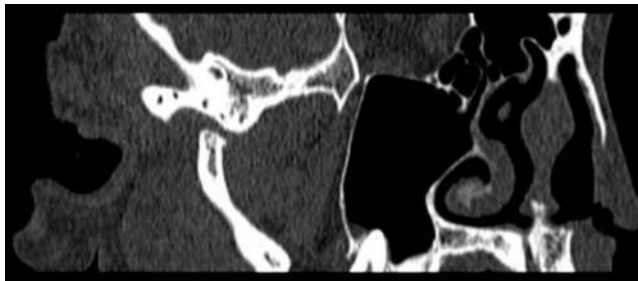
Sagittal view of the CT, right TMJ in an open mouth position. Sign of flattening of the mandibular condyle.
